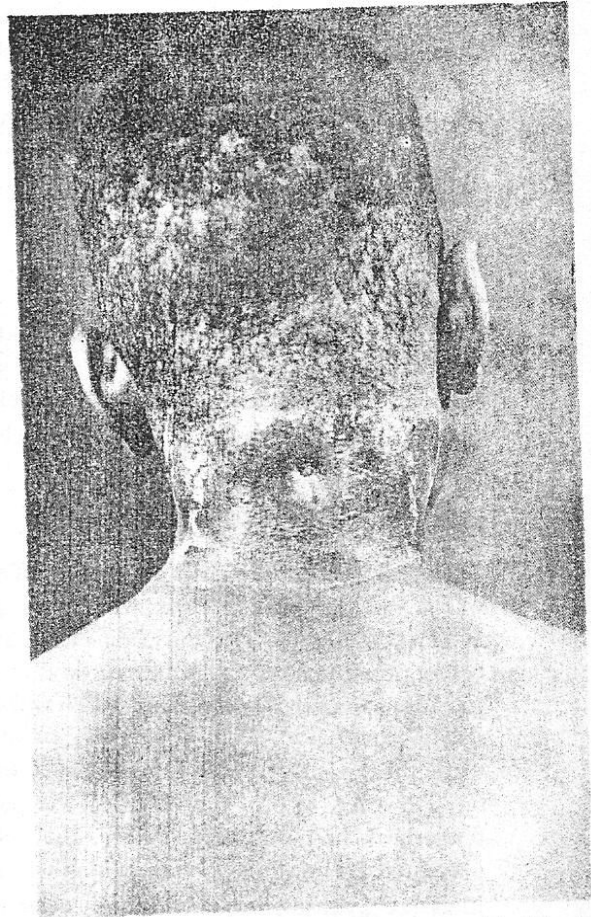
Cervical gibbus with a sinus, in a 9-year old girl with spinal tuberculosis. X-ray revealed osteitis of C7.
